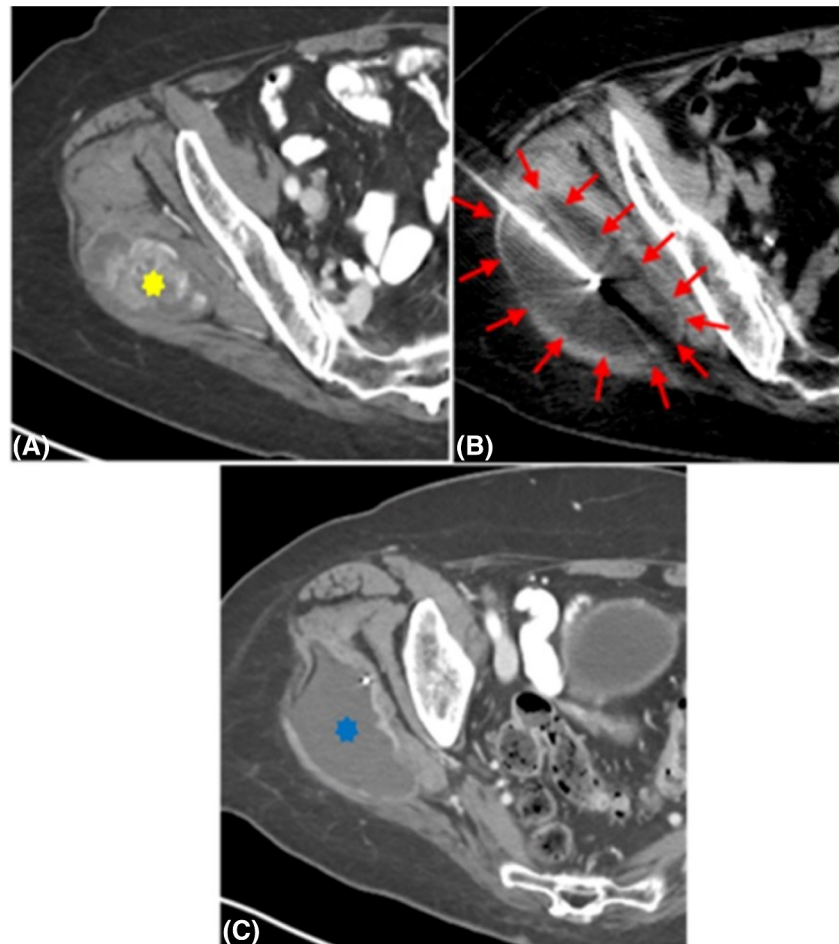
A woman aged 71 years with leiomyosarcoma metastasis to the right gluteal musculature. (A) Contrast-enhanced computed tomography showing a soft tissue mass (red asterisk) in the right gluteal musculature consistent with leiomyosarcoma metastasis. (B) The metastatic lesion was treated with percutaneous cryoablation (red arrows) under computed tomography image guidance. To prevent injury to the adjacent sciatic nerve, continuous electromyography and somatosensory evoked-potential monitoring was performed throughout the procedure. (C) Follow-up imaging at 3 months demonstrated successful local control of this lesion, with extensive necrosis (blue asterisk) throughout the tumor.
